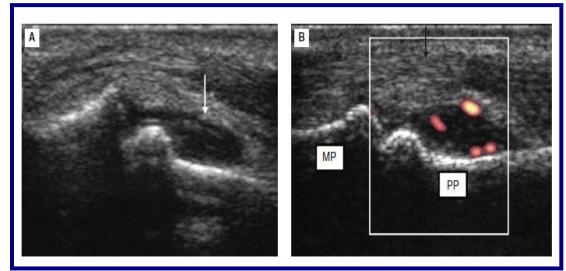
Longitudinal image of flexor aspect of PIP joint showing hypoechoic synovial hypertrophy distending the synovial recess (Image-A, white arrow). B Moderately increased vascularity on power Doppler. PP = proximal phalanx, MP = middle phalanx. Flexor tendons (black arrow). (6)
